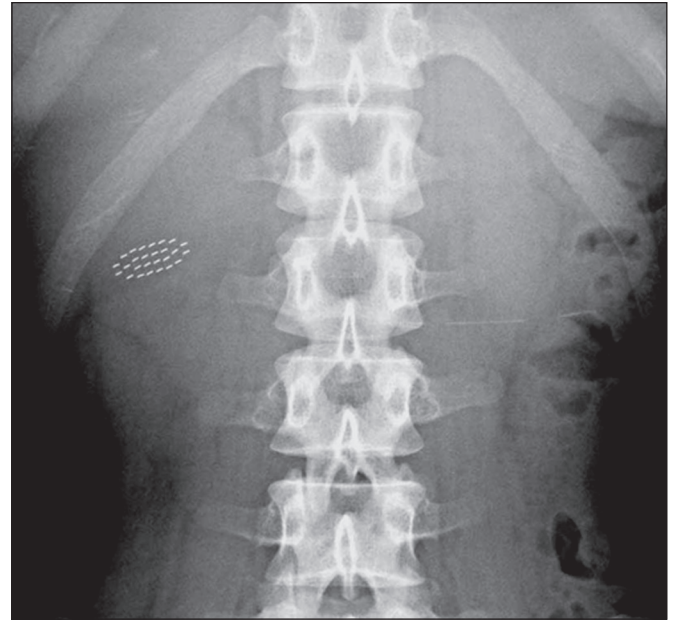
A 35-year-old intellectually disabled woman who swallowed a small toothbrush. On the anteroposterior radiograph of the abdomen, radiopaque bristles are seen in the right colic flexure. The brush passed without difficulty.
